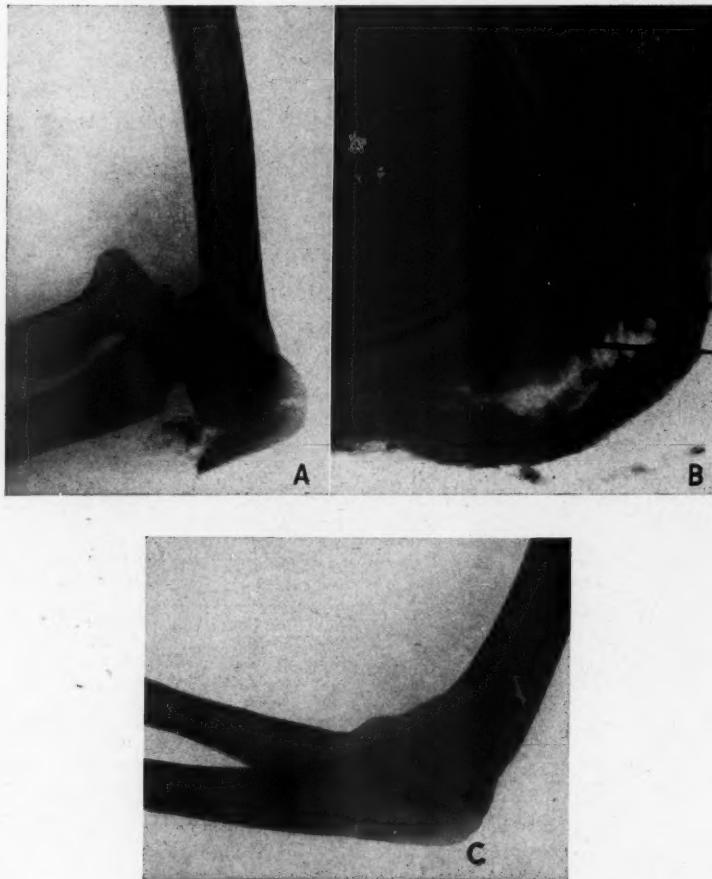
N. B. W. Male, 47. *A.* Fracture of left olecranon and anterior dislocation of the elbow. *B.* Fracture of olecranon reduced and fragments replaced in their normal position. Olecranon anchored with two crossed Kirschner wires. Wires removed at the end of 4 weeks. *C.* X-ray 2 months after the accident. Olecranon well united in perfect position. Good joint function.
